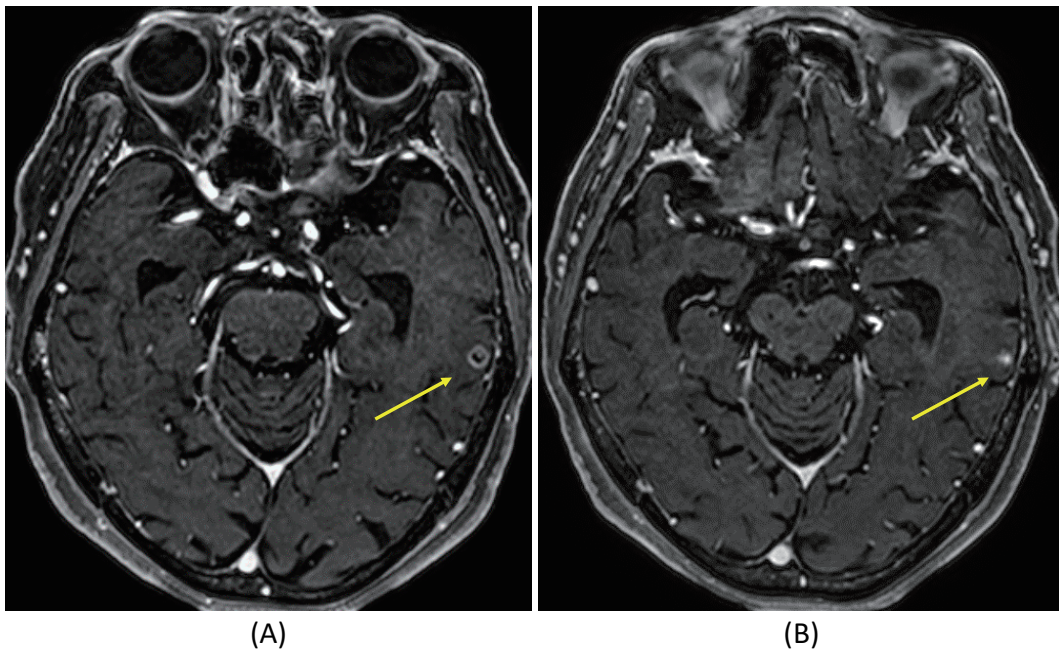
Contrast-enhanced MRI of the brain. A: At the diagnosis, a contrast-enhanced nodule was observed in the left temporal lobe (yellow arrow). B: Four months after the initiation of osimertinib, MRI showed a reduction in the size of the metastatic lesion of the brain (yellow arrow). MRI: magnetic resonance imaging.
